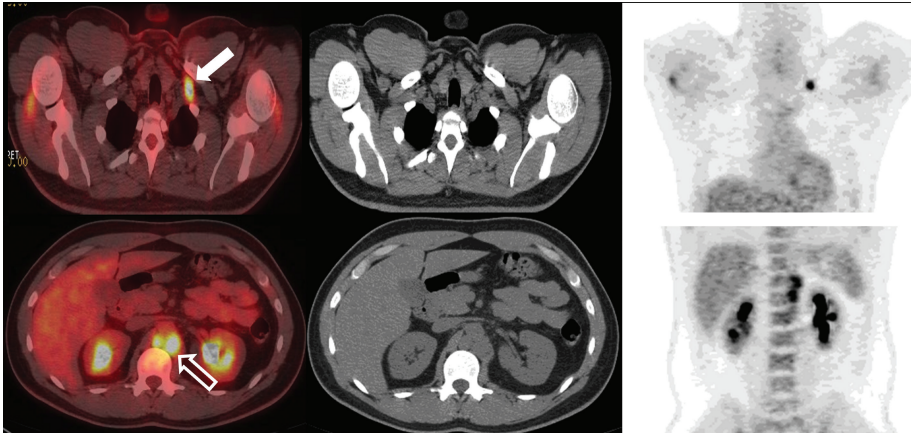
Lymph nodes. FDG PET/CT demonstrates hypermetabolic activity within left supraclavicular (thick solid arrow) and periaortic lymph nodes (thick open arrow). This patient was undergoing restaging for a history of seminoma. Findings on PET/CT were consistent with retroperitoneal and left supraclavicular nodal disease.
